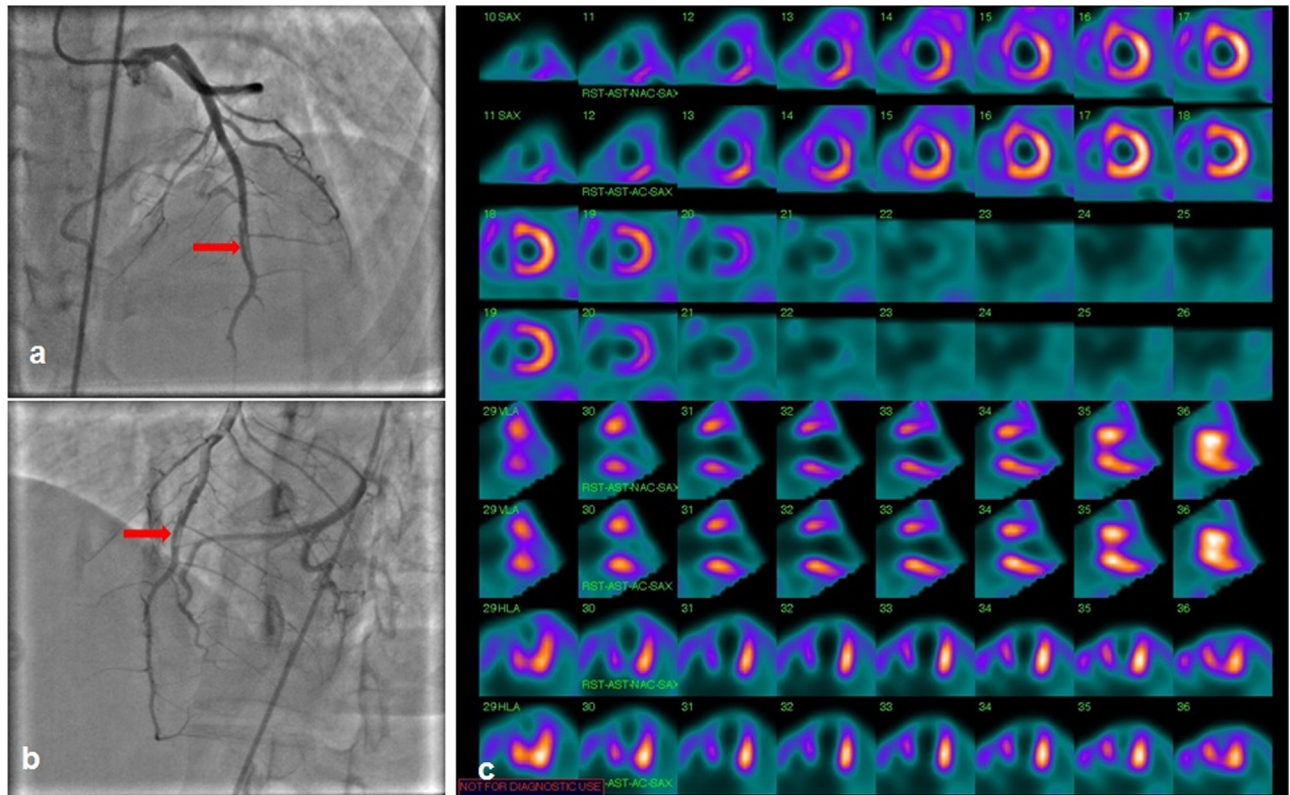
Coronary angiography in 25-year old female showed spontaneous coronary artery dissection in the distal left anterior descending artery (a, b). Tc-99m sestamibi SPECT/CT MPI revealed predominantly non-viable myocardium involving apex, parts of apical segments, mid anterior segment and part of mid septum involving ~34–36% of LV myocardium (c).
